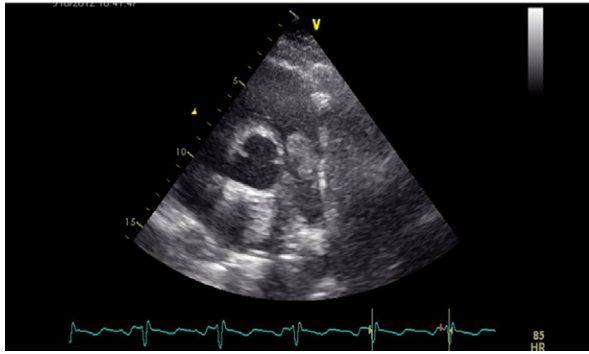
Transthoracic echocardiogram shows a 2.7 × 1.3-cm mass extending from the pulmonary valve into the pulmonary artery.
